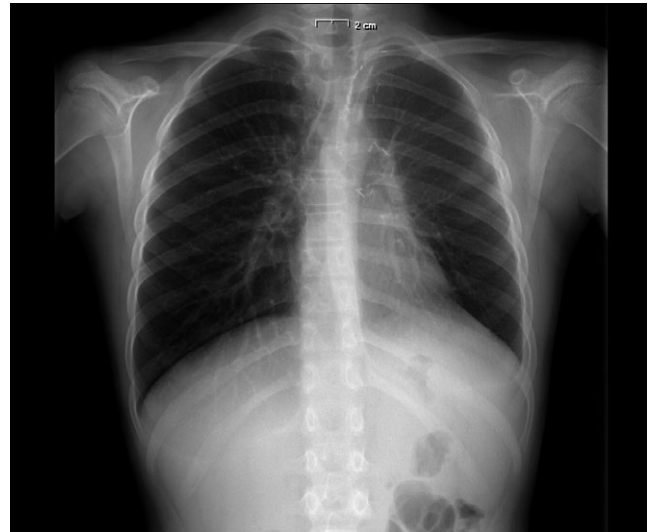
(X-ray): Left pulmonary upper lobe occupied by oval expansive formation of 8 × 5 cm
